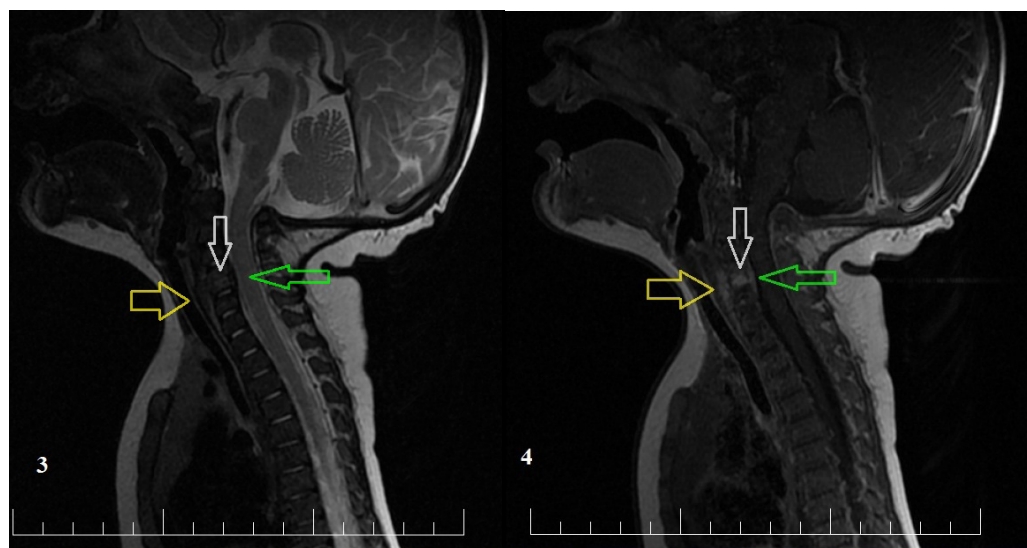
T2-weighted sagittal MRI of the cervical and thoracic spine showing considerable reduction of the magnetic signal at the level of the intervertebral disc C5-C6 (white arrow) and of the epidural collection (green arrow). Also the retropharyngeal space is no longer widened (yellow arrow).
